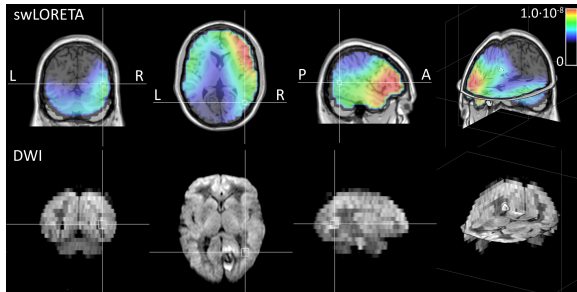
swLORETA reconstruction of EEG recording with a segment length of 40 min. The color bar indicates current density probability, with red and black representing high and low probability, respectively. Note the L-R orientation of the MRI image, analogous to Fig. 2.
